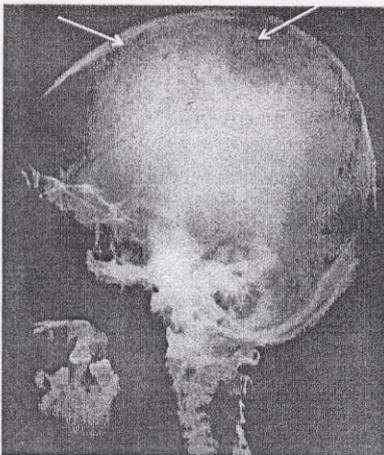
X-ray of the skull (lateral view): the white arrows show multiple lytic lesions over the skull.
